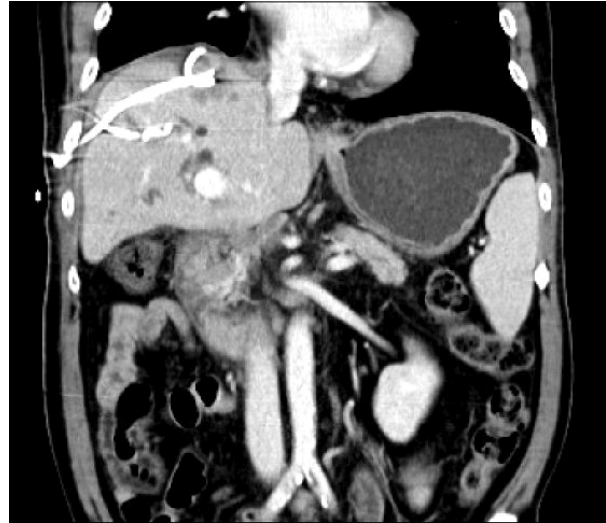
A follow-up computed tomography shows liver abscess with inserted pigtail catheter in the previous radiofrequency ablated site (black circle) and consolidation with air formation in the adjacent diaphragm, which was diagnosed as a lung abscess (white circle).
